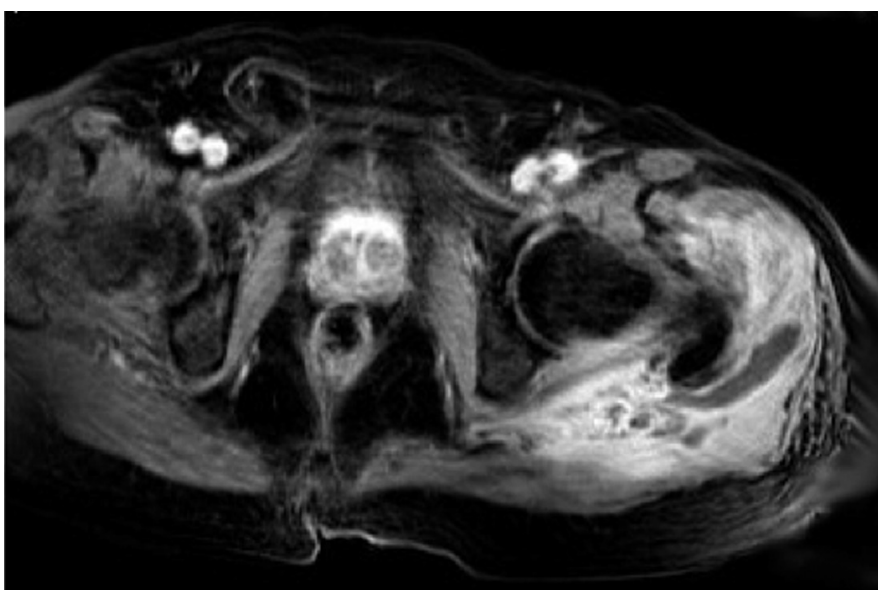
MRI of the hips: (T1 FS + contrast image) demonstrates left sided gluteal region muscle oedema with diffuse enhancement and intramuscular collections with peripheral enhancement.
